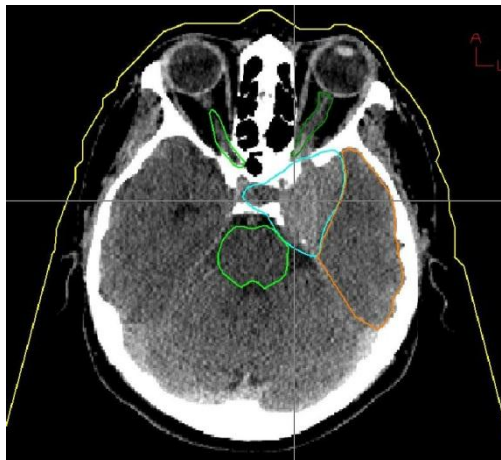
Contoured border of the irradiation target and critical structures on the axial CT slice
